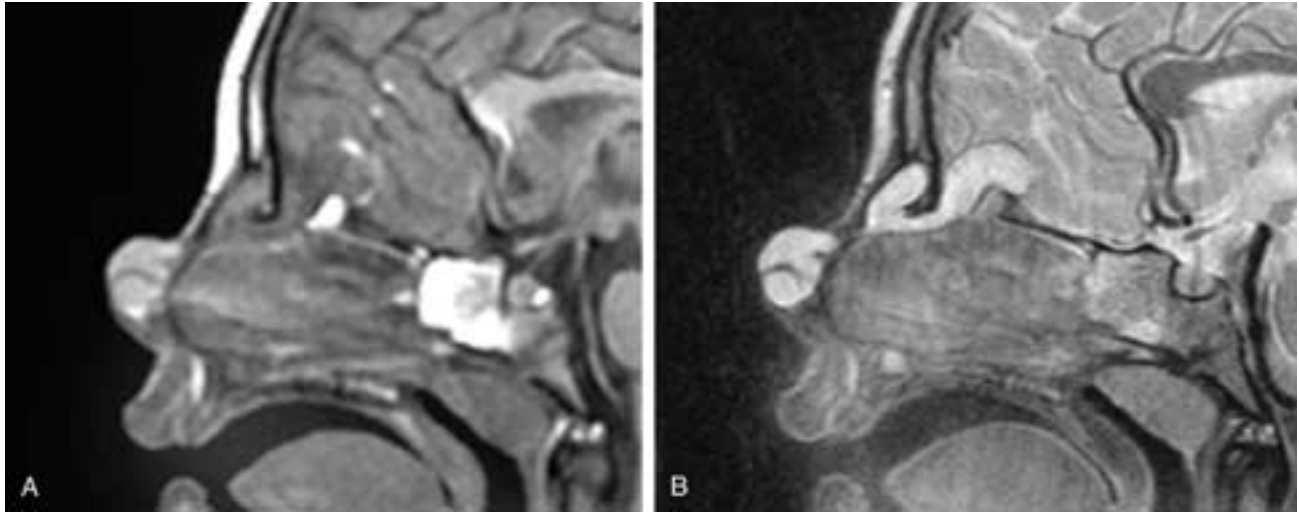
Nasal dermoid with intracranial extension. A and B, Sagittal T1-weighted (A) and T2-weighted (B) MR images in a 2-year-old girl with a bulbous nasal tip. The lesion expands the nasal tip and continues via a narrow tract to the glabella, where it forms a confluent transcranial mass at the glabella, the expanded prenasal space, the expanded foramen cecum, and the midline interdural space between the two leaves of the falx.
